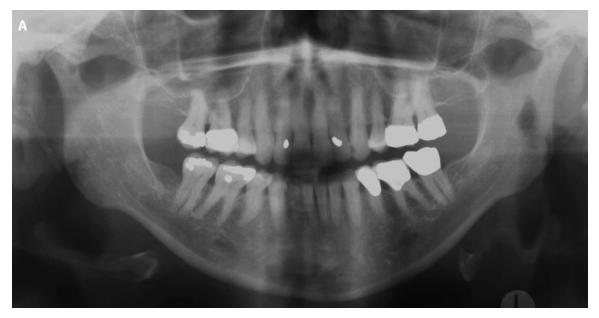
Panoramic radiograph showing poor visualization of right and left condylar heads.
